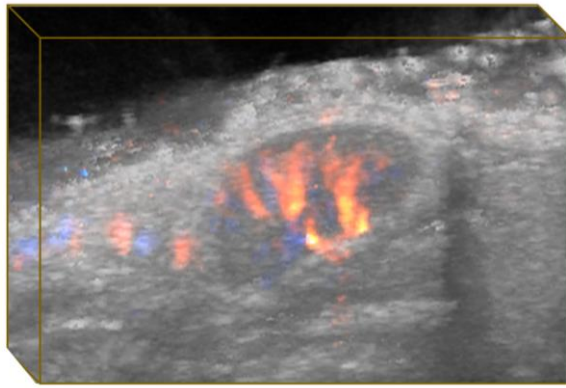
3-D Doppler image demonstrating the enlarged inguinal lymph node and dilated vasculature.
